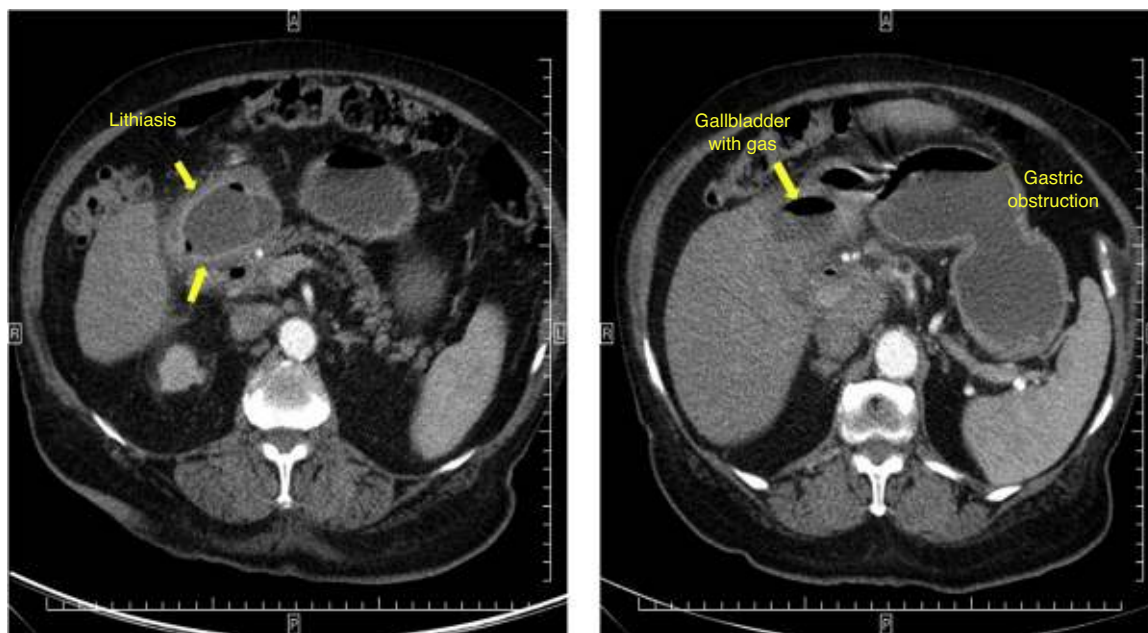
Abdominal CT scan showing impacted lithiasis at the pyloroduodenal level and the gastric obstruction.
